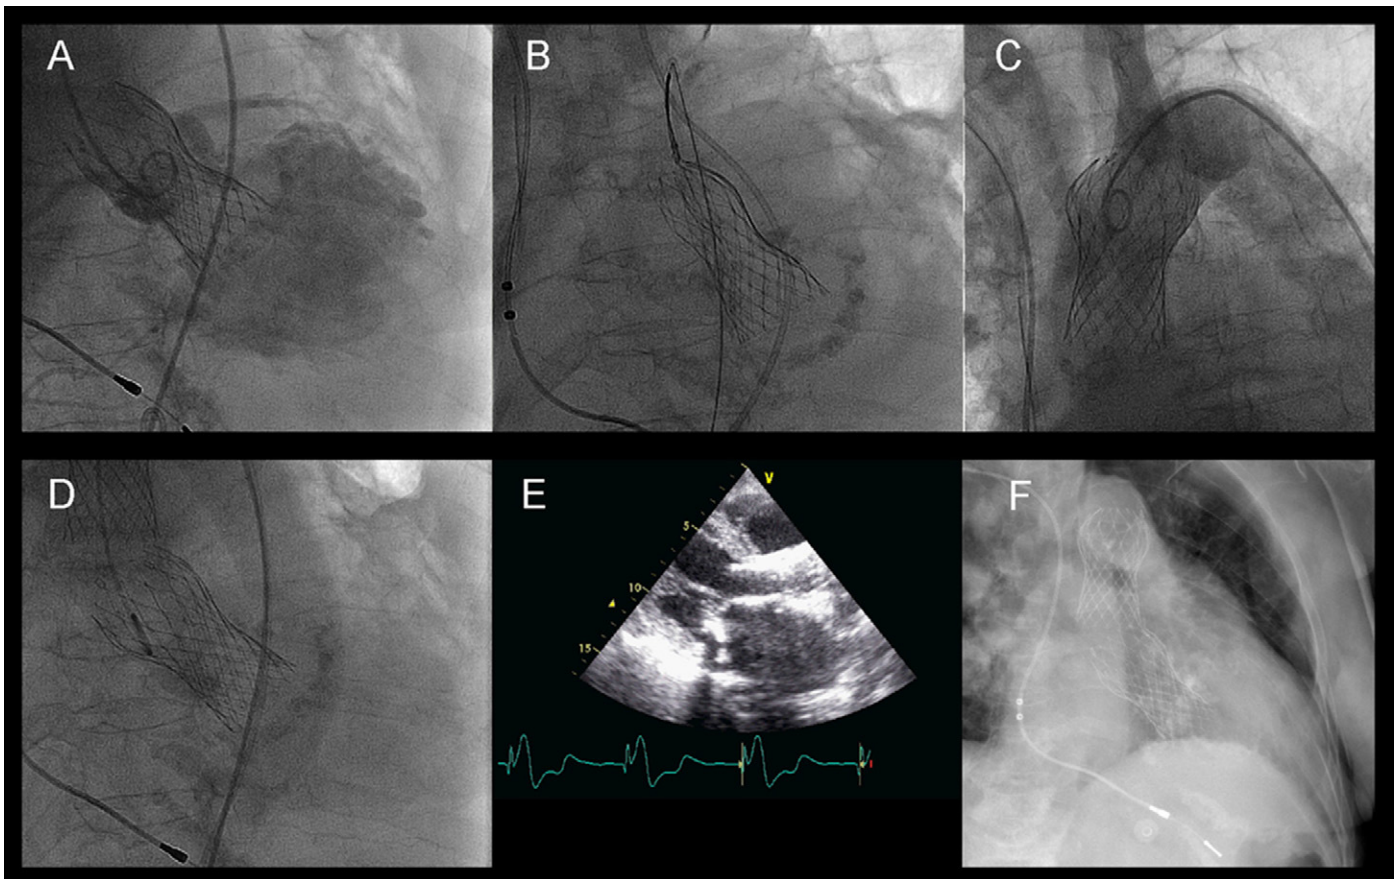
A: angiographic image showing moderate-to severe aortic insufficiency due to low implantation of the prosthesis. B: traction using a snare catheter. C: relocation of the prosthesis in ascending aorta; the patency of the supraaortic vessels can be observed. D: implantation of the second prosthesis. E: echocardiographic follow-up showing the situation of both prostheses. F: computed tomographic image showing the situation of both prostheses.
